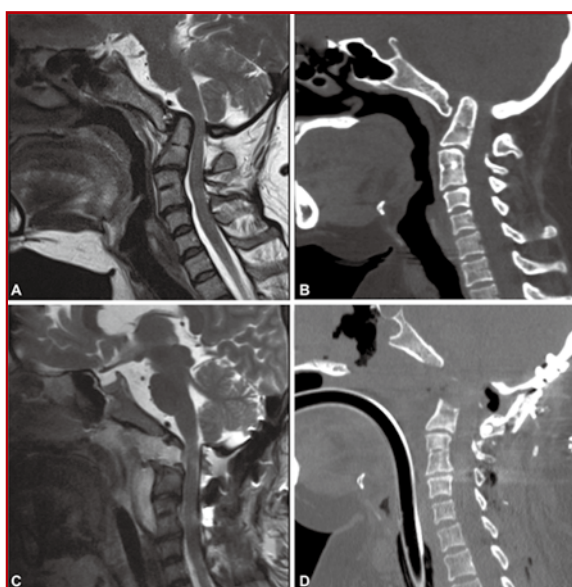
MRI and CT showing pre-op imaging of a patient with basilar invagination and after endoscopic odontoidectomy and posterior fixation. Excerpted from reference 5
